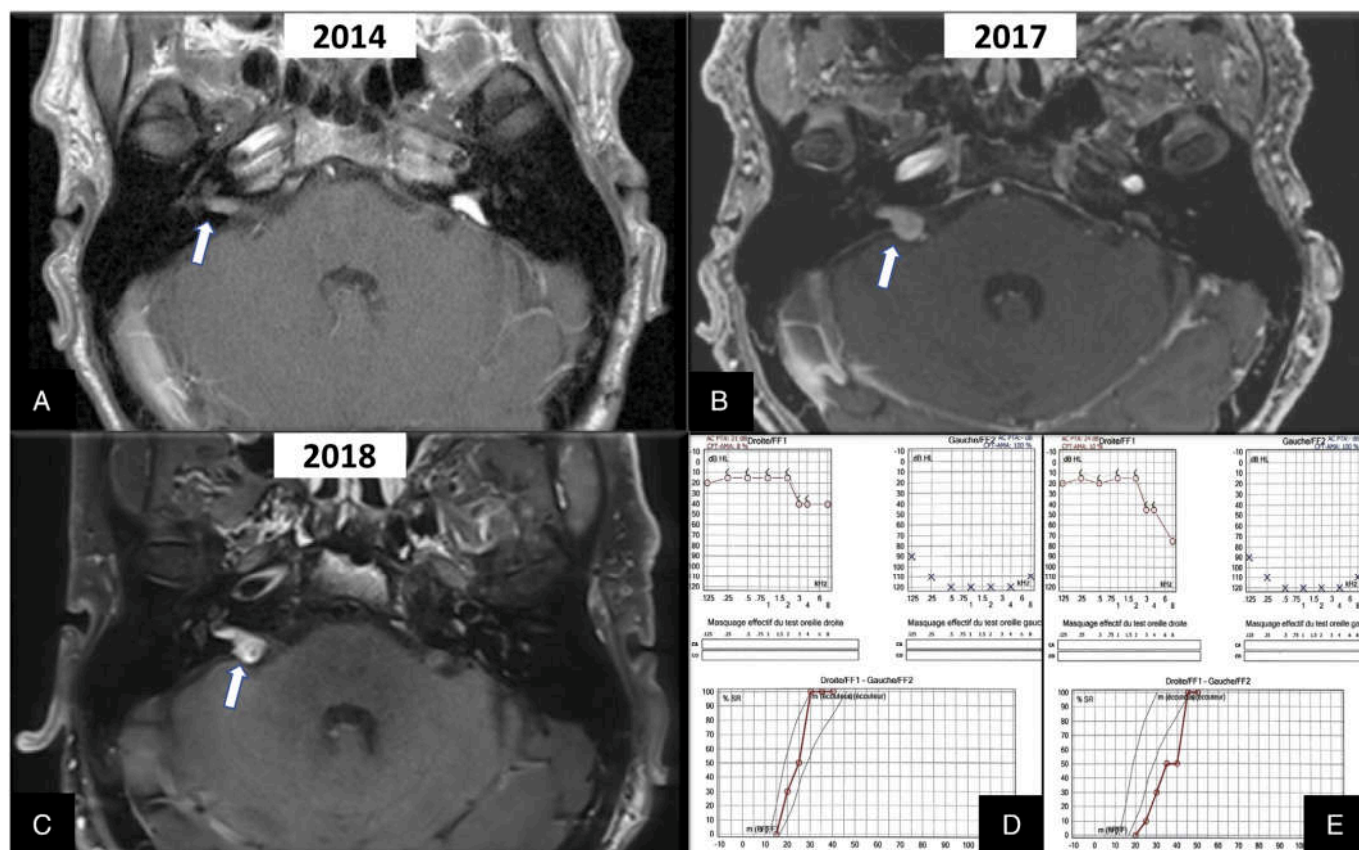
Case 1. (A) Postoperative axial T1-weighted gadolinium-enhanced magnetic resonance imaging (MRI) showing contralateral right-side intracanalicular vestibular schwannoma (VS) (white arrow) 14 years after left VS removal. (B) MRI showing growth of the tumor (stage II) in 3 years (white arrow). (C) Follow-up MRI after chemotherapy with no VS evolution (white arrow). (D, E) Audiometric evaluations before (D) and after (E) treatment with bevacizumab showing slight high frequencies and speech recognition threshold decline. [Color figure can be viewed in the online issue, which is available at [www.laryngoscope.com](http://www.laryngoscope.com).]
